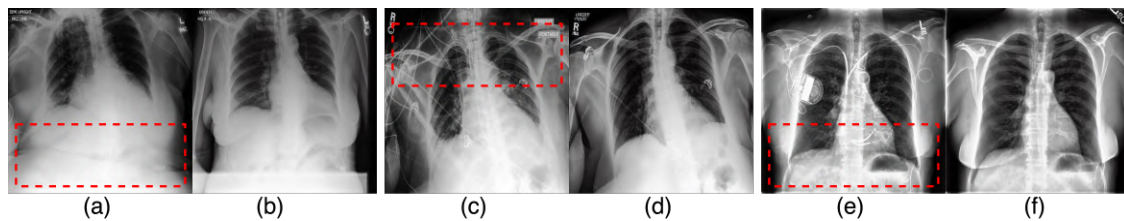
Examples of original (a, c, e) and CF image (b, d, f) pairs. The command was to remove the support device, and the edits were inconsistent with the expected outcome. Red boxes highlight areas where the changes are not as intended. (a-b): The radiograph shows a problem with the original image (at the bottom). The edited image incorrectly modifies this region instead of retaining it. (c-d): The red-boxed region contains multiple tubes. While removing the tubes, the model recreates the missing anatomical area improperly. (e-f): When removing the medical devices, the subject is depicted more strongly as female
